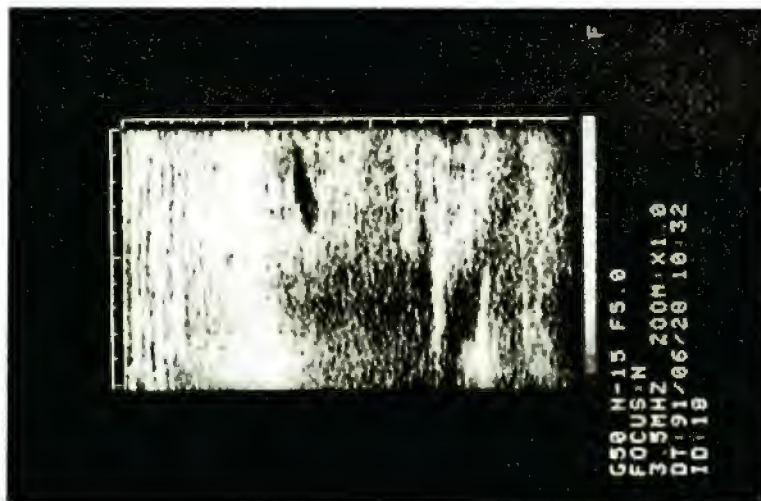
Ultrasonogram of hepatic amyloidosis.
